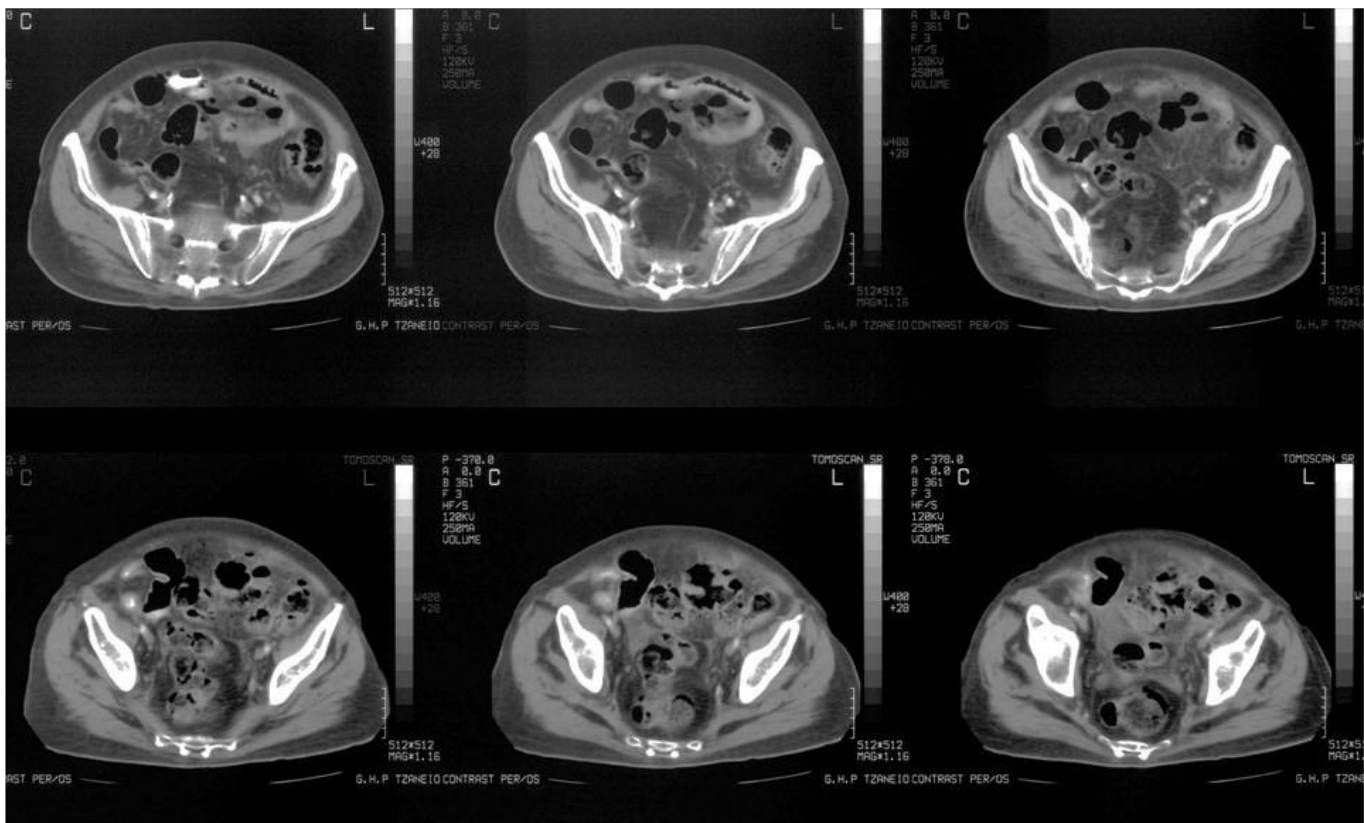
Abdominal computed tomography demonstrated wall thickening of the sigmoid and descending colon, inflammation of the pericolic fat with associated extraluminal air and free peritoneal fluid in the pelvis.
